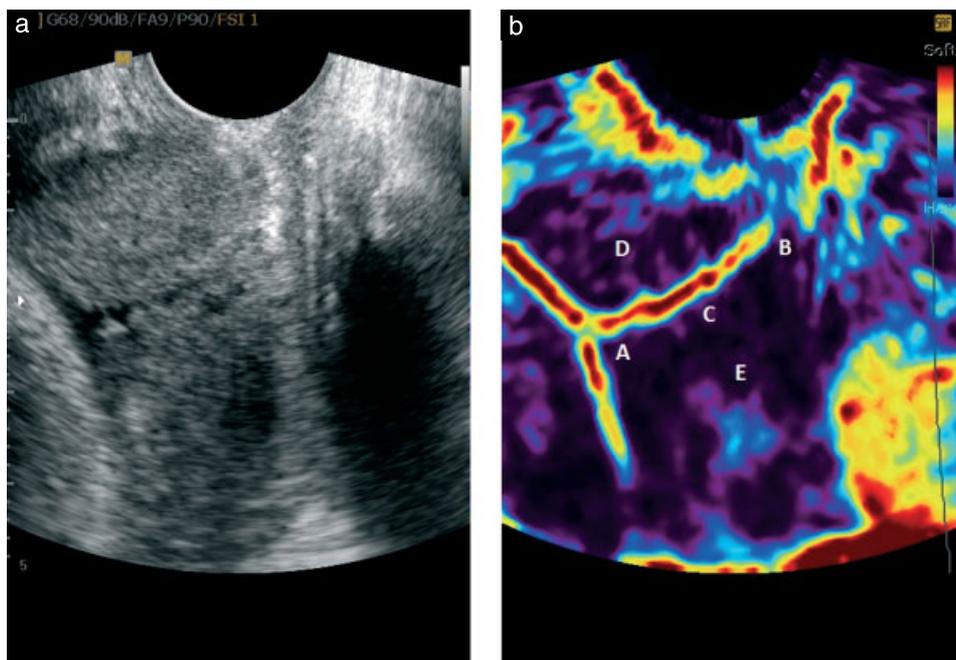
Elastography of the uterine cervix with soft cervical canal and orifices. (a) Gray-scale ultrasound image of the uterine cervix. (b) Elastogram showing differences in the stiffness of uterine parts visualized as different colors. A, internal os; B, external os; C, cervical canal; D, anterior wall of the cervix; E, posterior wall of the cervix.
